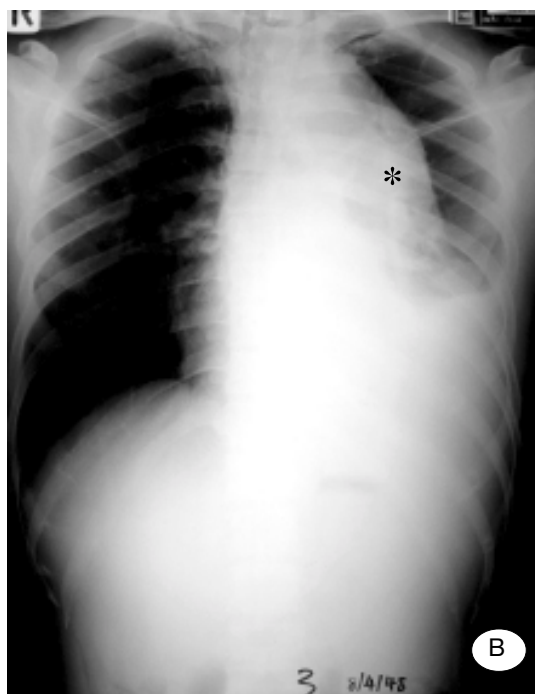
Chest PA radiograph (A), 2 years before surgery; mild dilatation of the aortic arch and descending aorta with right tracheal deviation(arrow).
